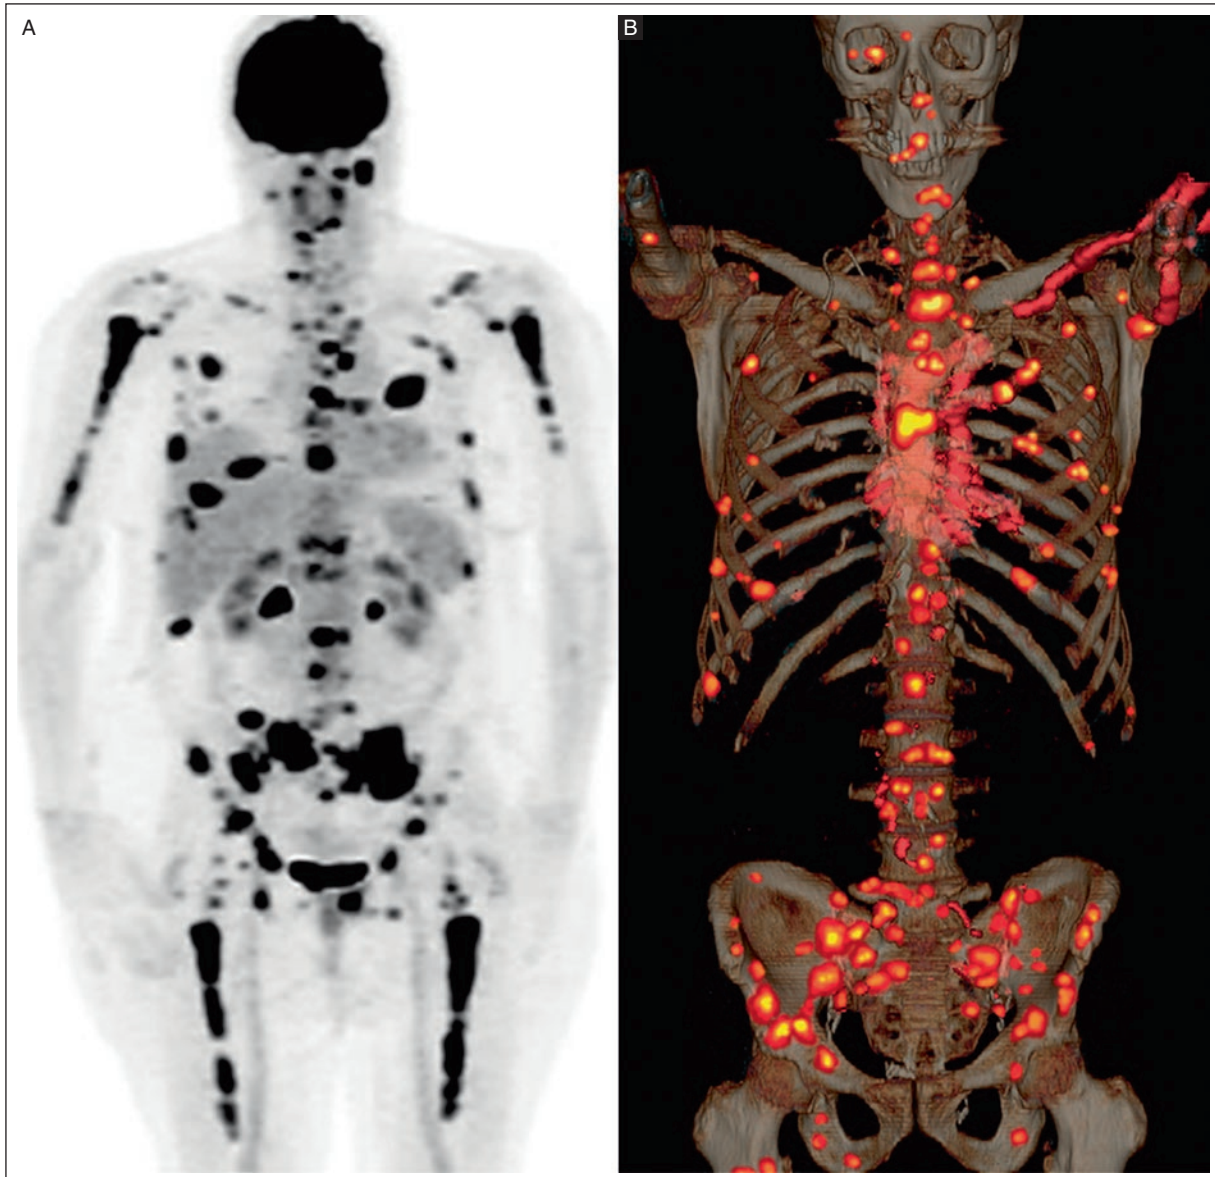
A: [^{18}F] FDG-PET scan of a patient with multiple myeloma, highlighting metabolic activity. B: 3D-rendered bone CT with PET-based tumor segmentation to quantify radiomic features.
